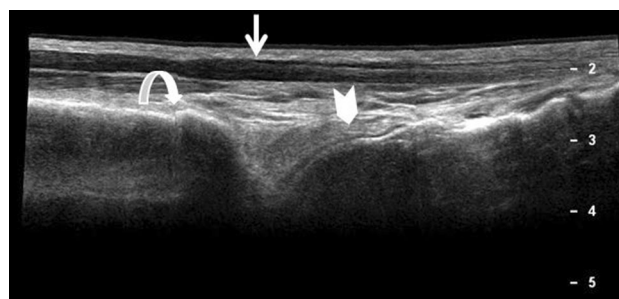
Anterior longitudinal sonographic image along the course of the tibialis anterior tendon (*arrow*) (*panoramic view*). The tendon itself, which has a typical fibrillar appearance, is seen running superficial to the anterior recess of the tibiotalar joint. The latter, which can be visualized only when it is distended secondary to effusion fluid, lies between the distal tibial epiphysis (*curved arrow*) and the talar dome (*arrowhead*)
